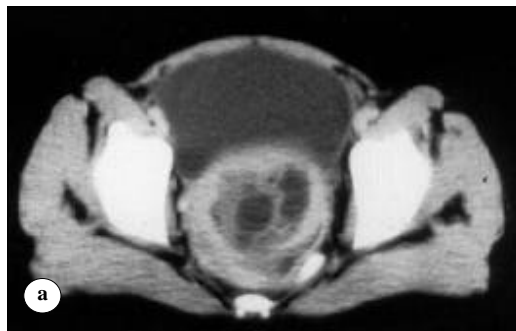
Pelvic CT reveals, (a) multiple cystic lesions in the uterus and (b) bilateral multiple adnexial cysts.
